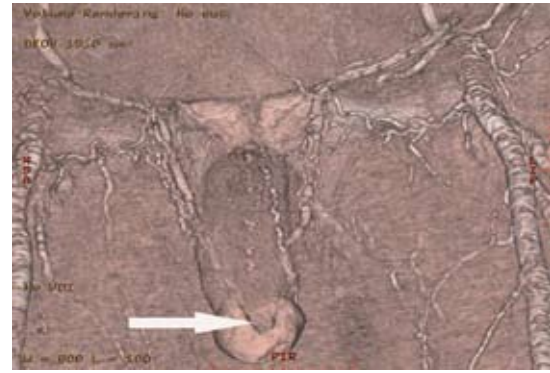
Computed tomography 3 dimensional reconstruction of the penis using volume rendering technique demonstrated the ulceration of glans penis and arterial wall calcifications.
